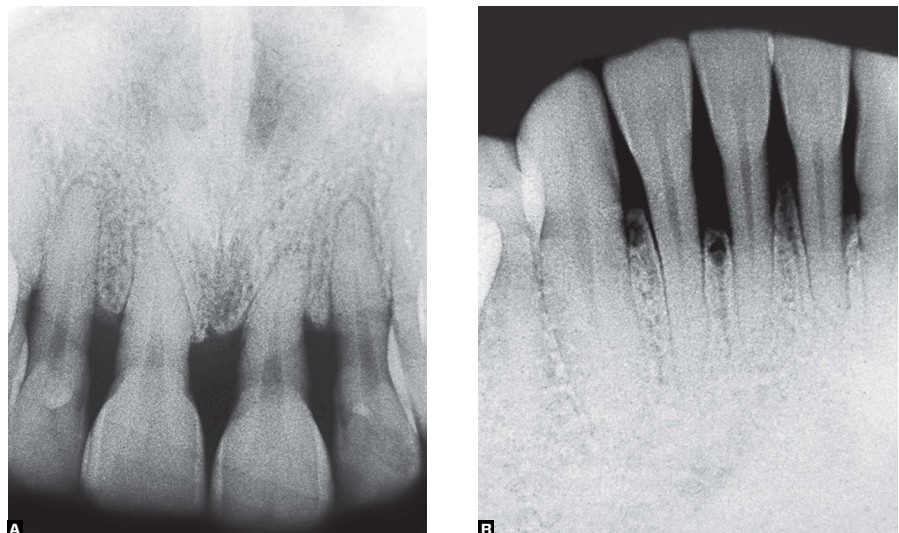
A, B) Initial radiographic aspects of type 1 diabetes patient. It can be observed periodontal destruction with apical migration of alveolar bone crests.
